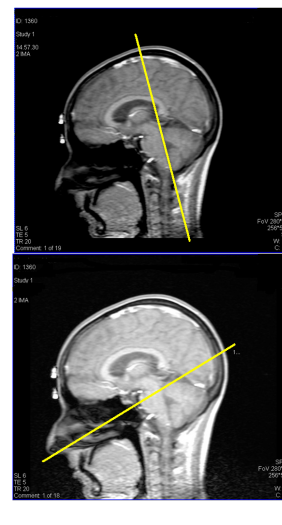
Phase Contrast MRI acquisition planes, for the detection of BVR (A) and SPS (B).
